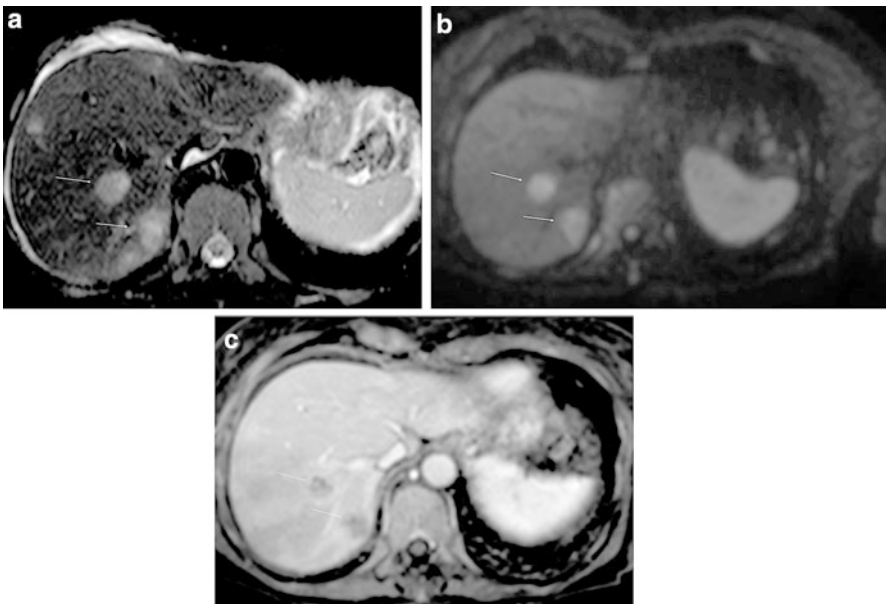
Selected images demonstrating liver metastases secondary to pancreatic adenocarcinoma. (a) Axial T2 weighted images of the liver demonstrating several liver metastases with a target-like appearance. Two of the lesions have been arrowed with a *white arrow*. There is also ascites in the upper abdomen. (b) DWI images demonstrating restricted diffusion of these visualized two lesions on this slice (*white arrow*). (c) Axial T1 weighted fat saturated post-contrast scans demonstrating irregular rim enhancement of these metastases (*white arrow*)
